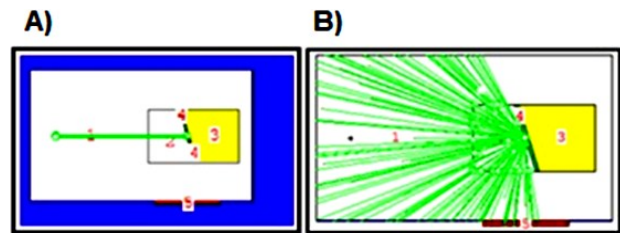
A) Visualization of 100 electrons emitted by the cathode of the point source, modeled with the visual editor of MCNPX. B) X-ray photons produced in the target for 10,000 particles.
